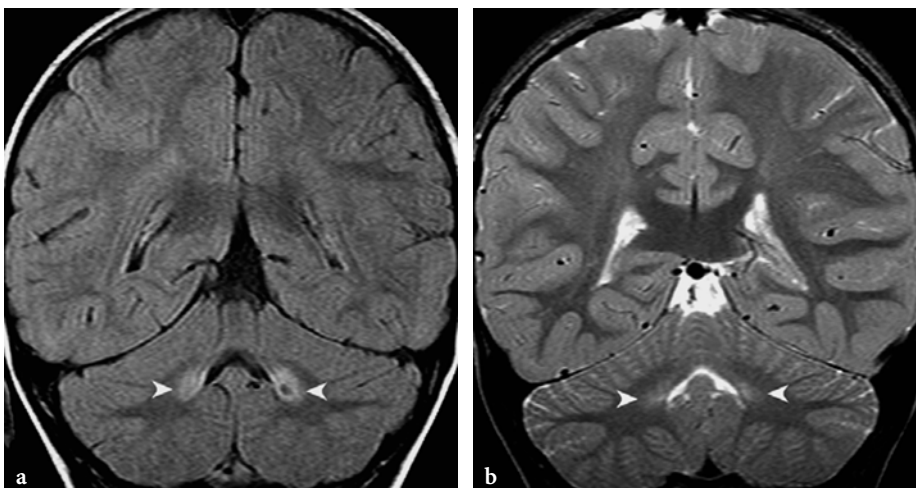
The MR imaging appearance of dentate nucleus lesions in biotin-responsive basal ganglia disease. a Coronal FLAIR image in a 17-month-old female patient. The dentate nuclei lesions are in the subacute phase. These exhibit prominent hypersignal without swelling (*arrowheads*). b Coronal T2-weighted fast spin-echo image in a 5-year-old female patient (same patient as in Fig. 13.126c). In this case, the dentate nucleus lesions are in chronic, atrophic phase already. The abnormal hypersignal is faint but still conspicuous (*arrowheads*)
